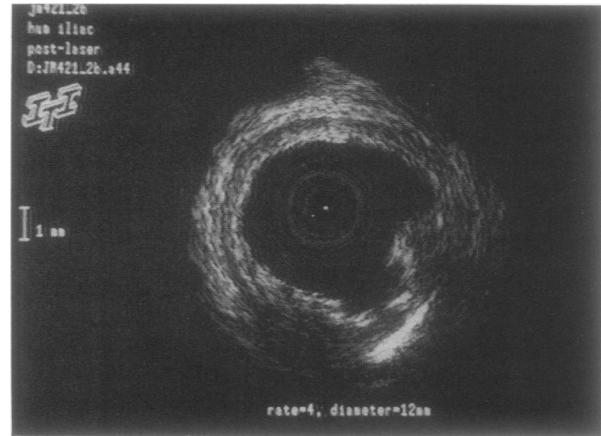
In this human iliac artery, destruction of the atherosclerotic plaque at 5 o'clock was due to photo-ablation with a bare Argon laser fiber. This *in vitro* feasibility study was performed with direct visual guidance, but it does show the ability of the ultrasonic imaging catheter to identify the portion of the arterial wall affected by atheroma. The potential benefit of this will be to guide a laser beam towards an atheromatous mass and away from a thin intima.
